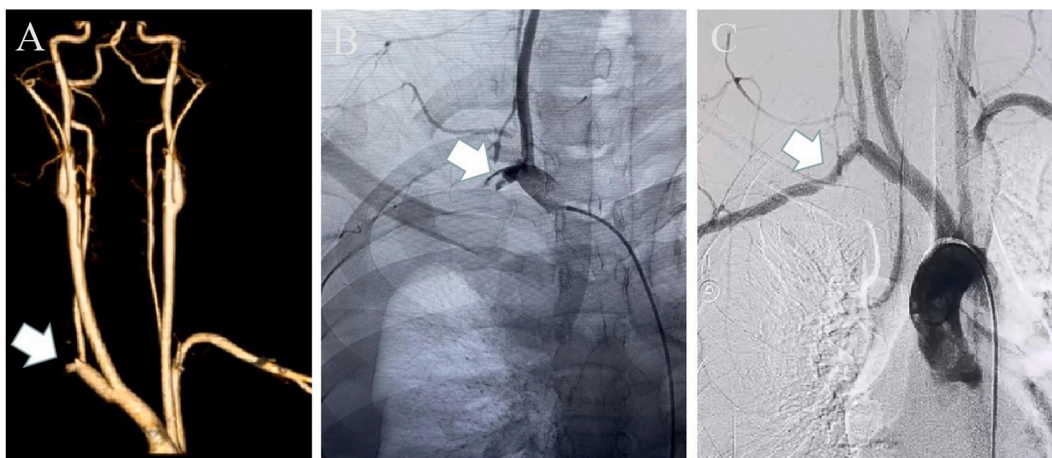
Preoperative and postoperative images of right subclavian artery occlusion. A and B. Cervical CTA and arteriography showed lumen occlusion of the initial segment of the right subclavian artery respectively (white arrow). C. Arteriography revealed that the right subclavian artery was patency after interventional endovascular thrombolysis (white arrow).
